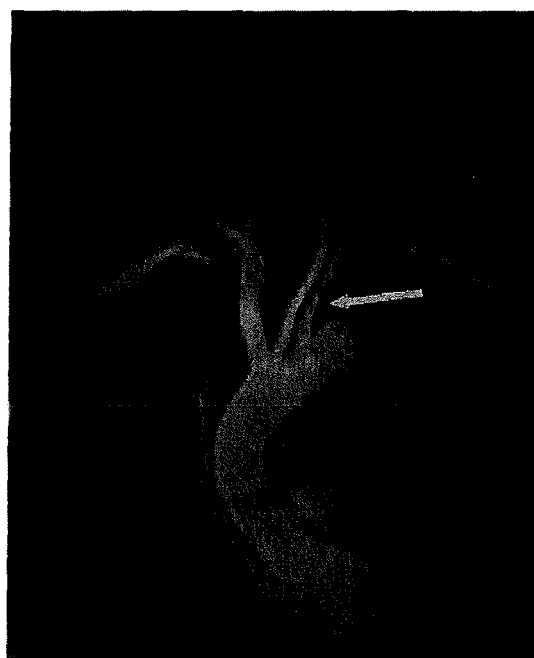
The contrast-enhanced T1-weighted 3D MR angiography is showing irregular vessel contours in the left subclavian artery (arrow) indicating a stenosis.
